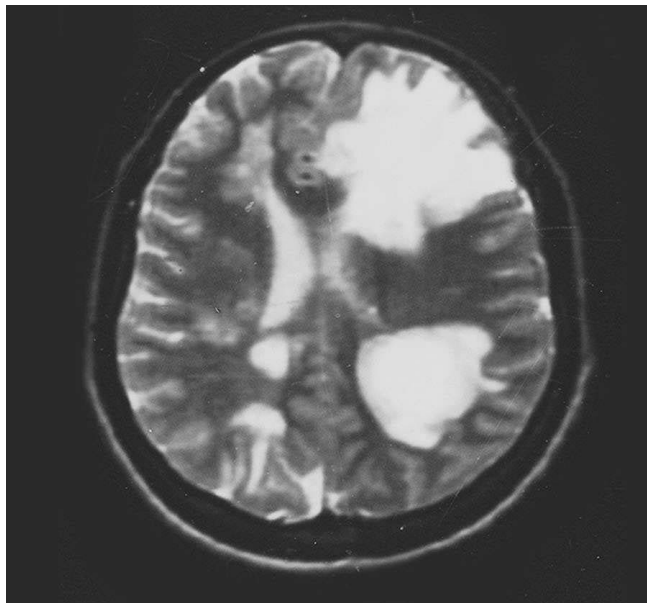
Axial MRI scan (T_2 -weighted sequence): During the aphasia, in the third exacerbation, new giant white matter lesions with mass effect especially in the patient's left cerebral hemisphere. The lesions on the right hemisphere in the previous attack have disappeared, and new giant plaques having shift effect on the lateral ventricle have occurred on the left side.
